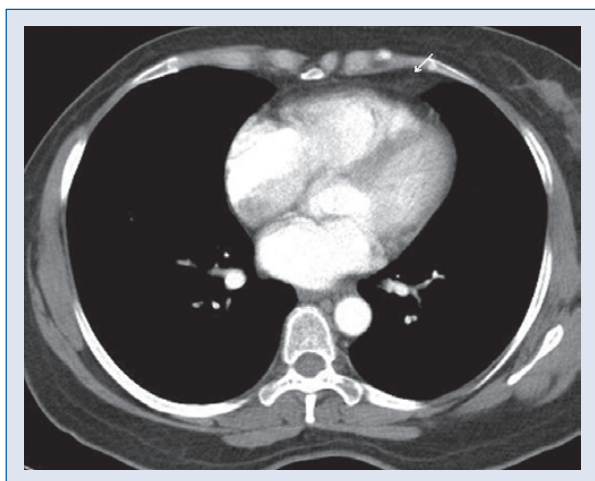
Follow-up computed tomography chest after 10 weeks shows marked resolution of the lesion.
